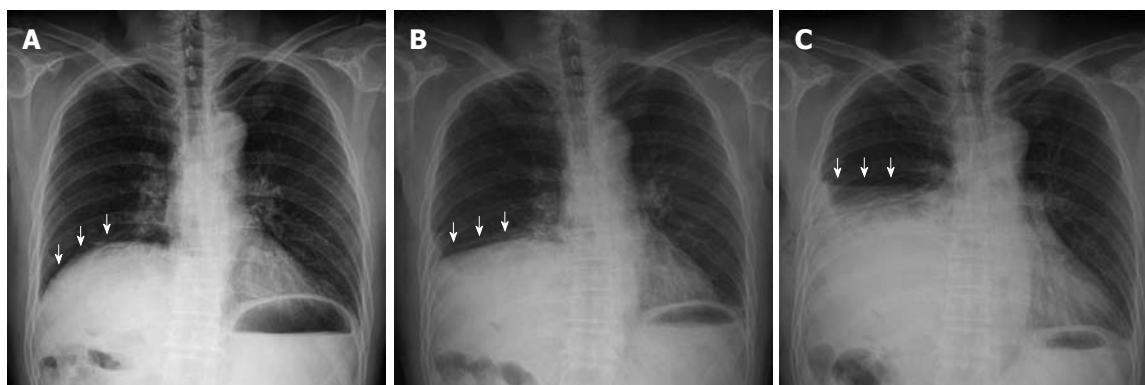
Gradual elevation of the right diaphragmatic border can be seen (arrows). A: Chest radiography on admission; B: Two hours after admission; C: After thoracostomy.
